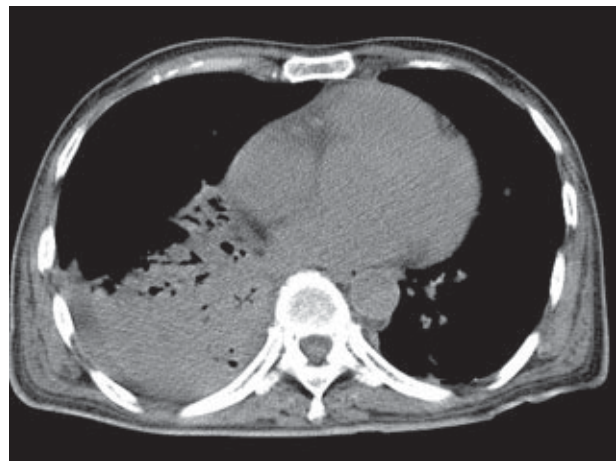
Chest computed tomography scan showing consolidation of pulmonary parenchyma with gas shadows in the right middle lobe and right lower lobe.
